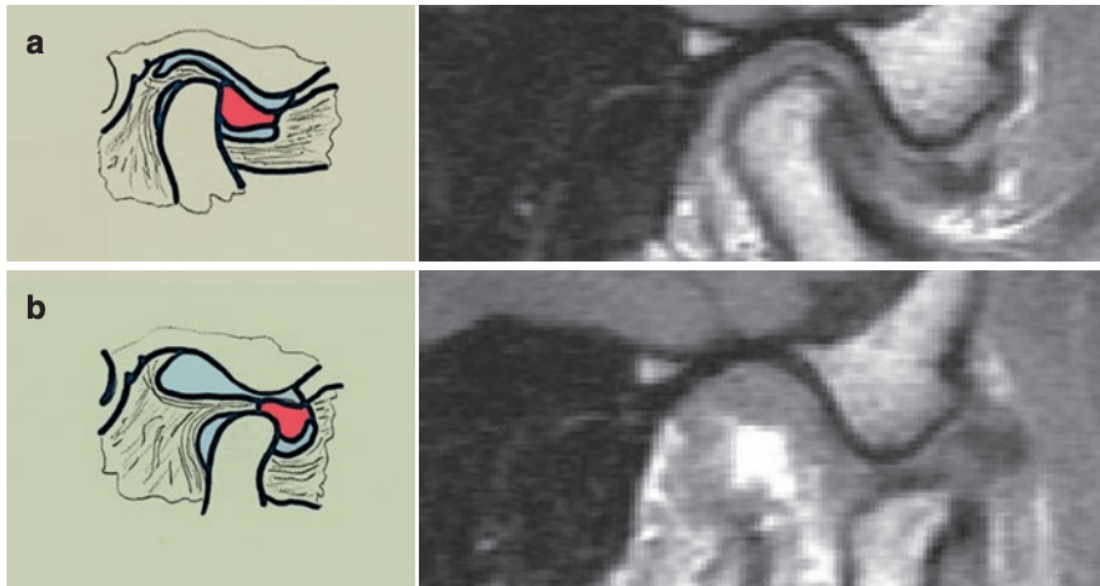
MRI of ADDwoR. MRI of ADDwoR: a) closed and b) open mouth positions (Bhargava, 2021)
